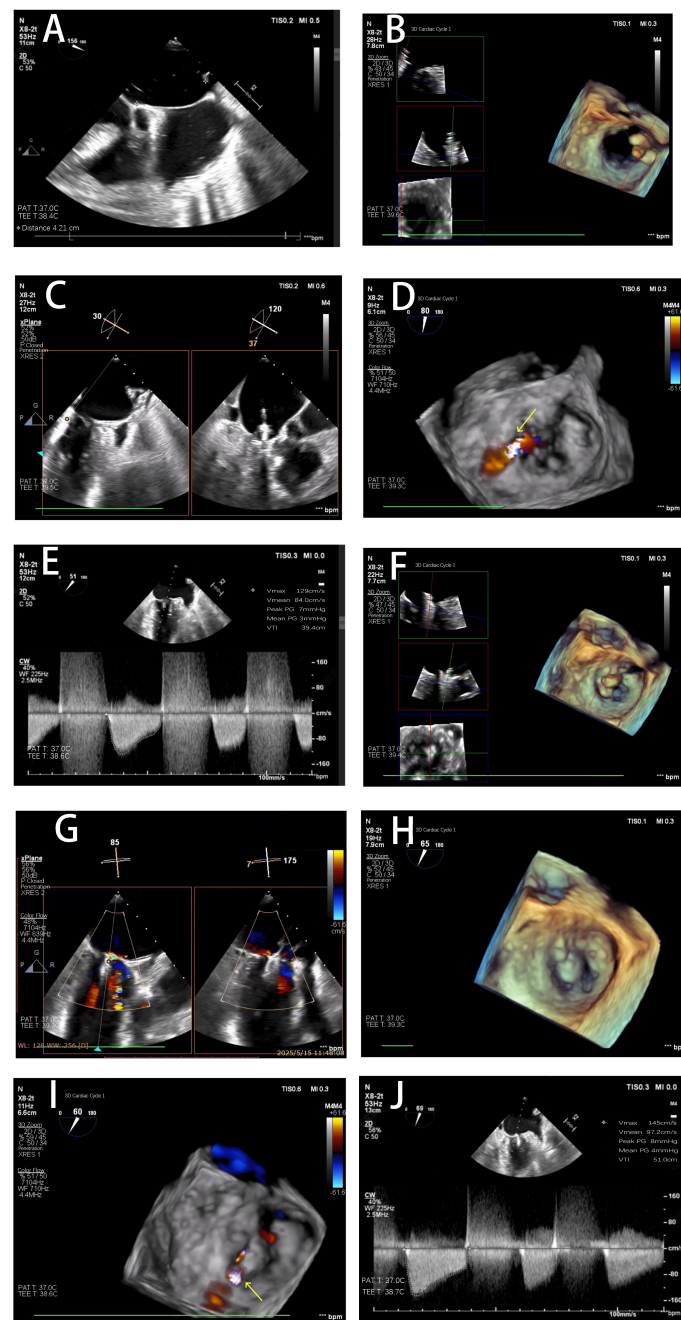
The Procedure of Mitral Transcatheter Edge-to-Edge Repair. (A) A posterior-superior atrial septal puncture was performed at a height of 4.21 cm from the mitral annular plane; (B) The SW0609 clip was oriented perpendicular to the line of coaptation (approximately 11 o'clock to 5 o'clock position) under 3D TEE guidance; (C) Both leaflets were on the clip arms; (D) Complete resolution of the P3-C2 prolapse with no residual regurgitation in that region after the first clip and significant residual MR from the untreated A1 prolapse persisted; (E) The mean trans-mitral pressure gradient (TMPG) measured 3 mmHg after the first clip; (F) The SN0409 clip was re-oriented (1 o'clock to 7 o'clock) to align with the anterolateral commissure; (G) Both leaflets were captured; (H) Stable tissue bridges on 3D imaging after the second clip deployment; (I) Only trace residual lateral MR were existed after the second clip deployment; (J) The final TMPG was 4 mmHg after the procedure. The yellow arrow indicated the residual regurgitation flow after clip deployment. TEE: Transesophageal echocardiography; MR: mitral regurgitation.
